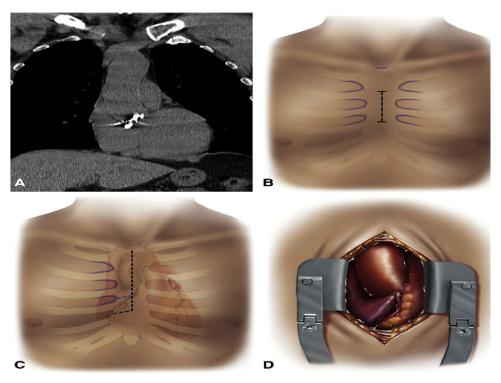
Upper hemisternotmy incision. (A) Preoperative chest computed tomography to identify the location of the aortic valve in relation to the sternum. (B) Skin incision for upper hemisternotomy. (C) J incision at the level of the third and fourth intercostal spaces. (D) Surgical exposure through an upper hemisternotomy; the ascending aorta and the right atrial appendage are clearly visible.¹⁰
